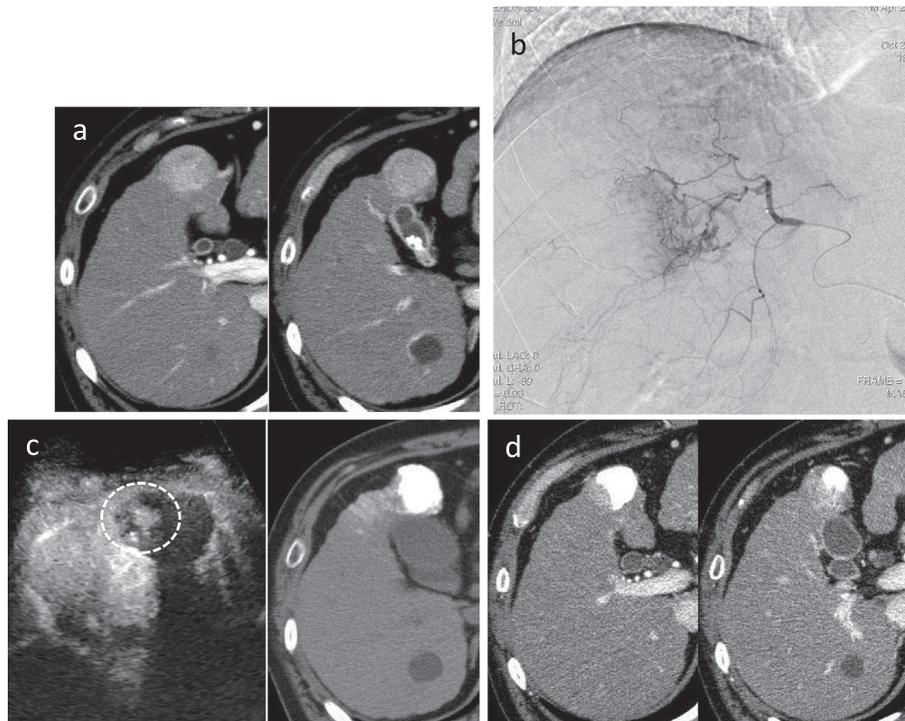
A case of S5 hepatocellular carcinoma (30 mm in diameter) treated using conventional TACE. (a) Uniform pachychromatic images in tumors in the arterial dominant phase in contrast-enhanced CT before treatment. (b) Angiography of the right hepatic artery was followed by TACE performed by inserting the catheter into the cephalic vein. (c) Contrast-enhanced ultrasonography on the day after treatment showing a pachychromatic region in the bottom of the tumor, and a non-contrast CT image on the day after treatment showing lipiodol accumulation corresponding to a TE4 efficacy evaluation. (d) Arterial dominant phase in contrast-enhanced CT 1 month after treatment, showing local recurrence. CT, computed tomography; TACE, transcatheter arterial chemoembolization.
